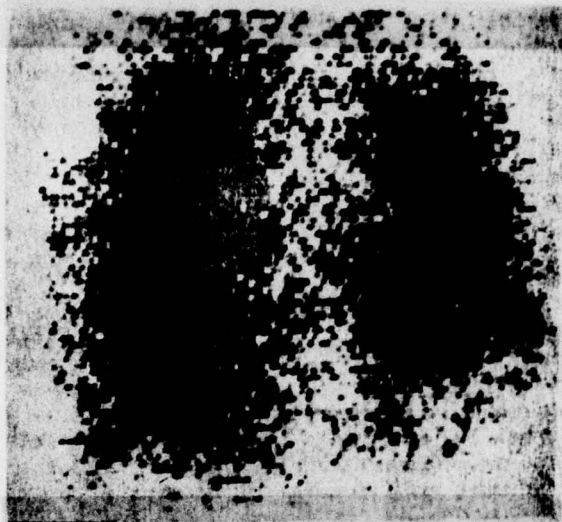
Perfusion scintigram (PA). Complete absence of perfusion in lower lobe of left lung. Suspected embolism of lower branch of left pulmonary artery.
